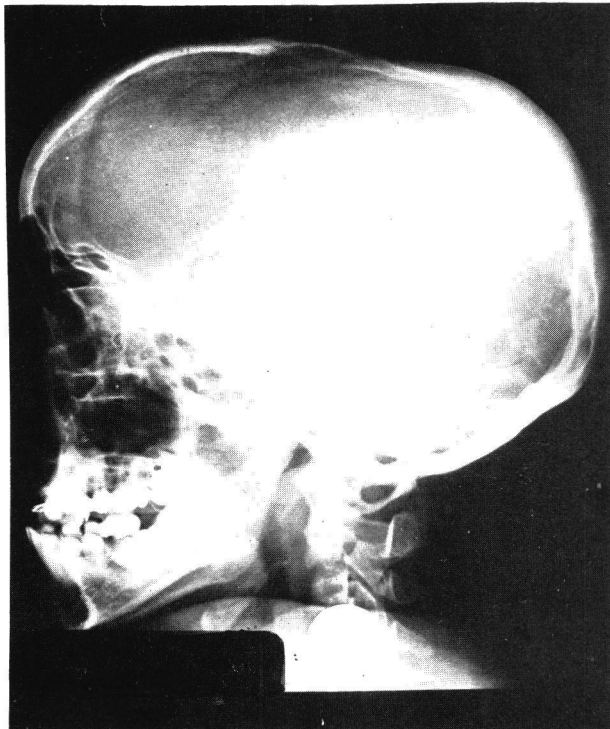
Radiograph of Skull showing Scaphocephaly and Exaggeration of Convolutional Markings.
